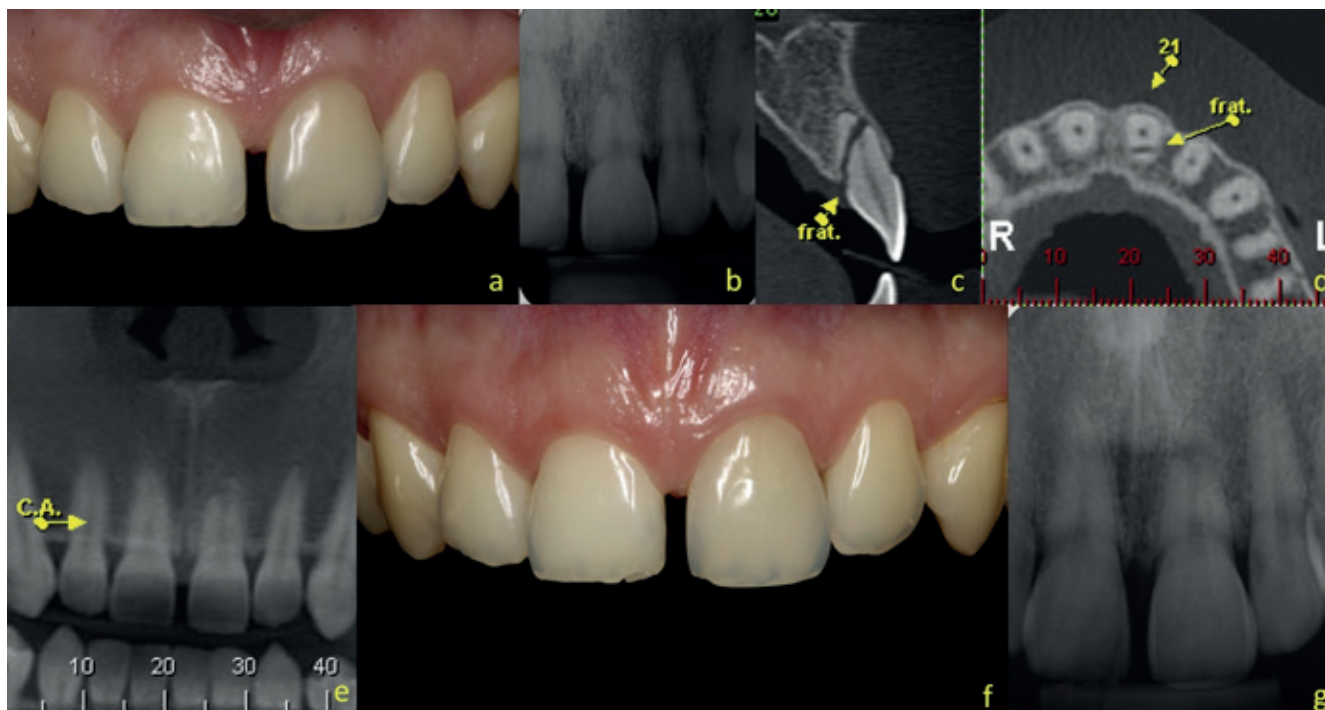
(a) Slight discoloration of the maxillary left central incisor. (b) A preoperative radiograph showing horizontal root fracture at the apical third of the left maxillary central incisor. (c) CBCT showing the sagittal (d) axial (e) and panoramic view. (f) Periapical radiograph at 2-year follow-up showing the interposition of soft tissue between the fragments. (g) Clinical aspect at 2-year follow-up.
